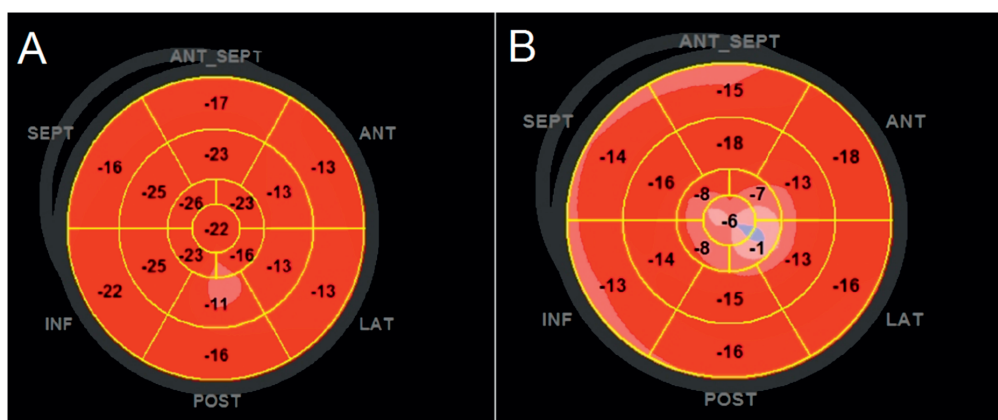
Example of changes in left ventricular global longitudinal strain (GLS) displayed in a bull's eye for the 17 left ventricular segments (color-coded from dark red, as preserved GLS, to pink/blue as impaired GLS). Panel A. Echocardiography with preserved GLS (-18.5%) in a 65-year old male patient in 2006. Panel B. Echocardiography in the same patients with a decline in GLS (-12.4%) in 2015. In 2016 this patient reached the heart failure endpoint.
